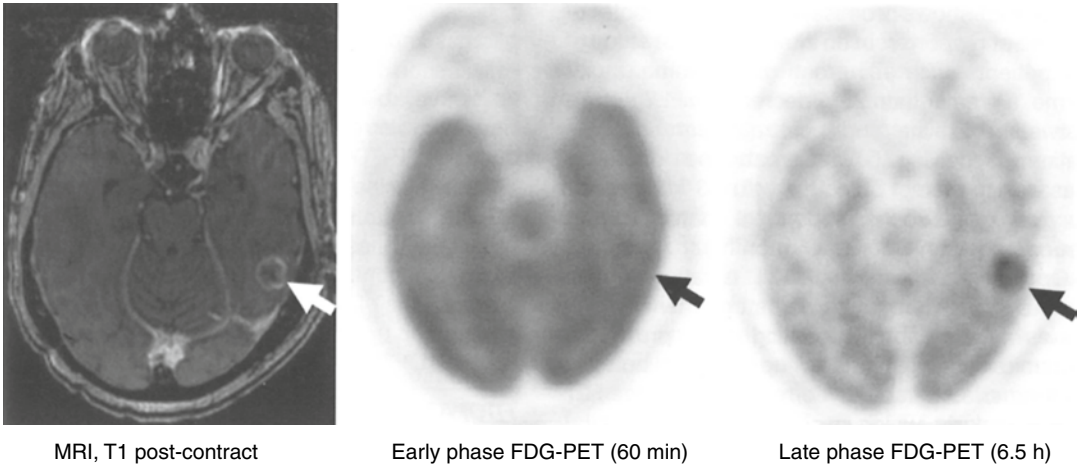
A 69-year-old man with non-small cell lung cancer metastatic to the left temporal lobe 6 months after chemoradiotherapy, with increasing size on MRI (*left*); arrow indicates the lesion. Lesion SUVmax increased from 4.7 to 7.5 between early phase images (*center*) performed 1 h after FDG tracer injection and delayed-phase
